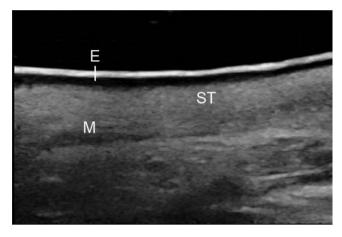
Ultrasonography image of the normal buccal tissue. E = epithelial membrane of buccal mucosa; ST = subepithelial connective tissue; M = buccinator muscle.
